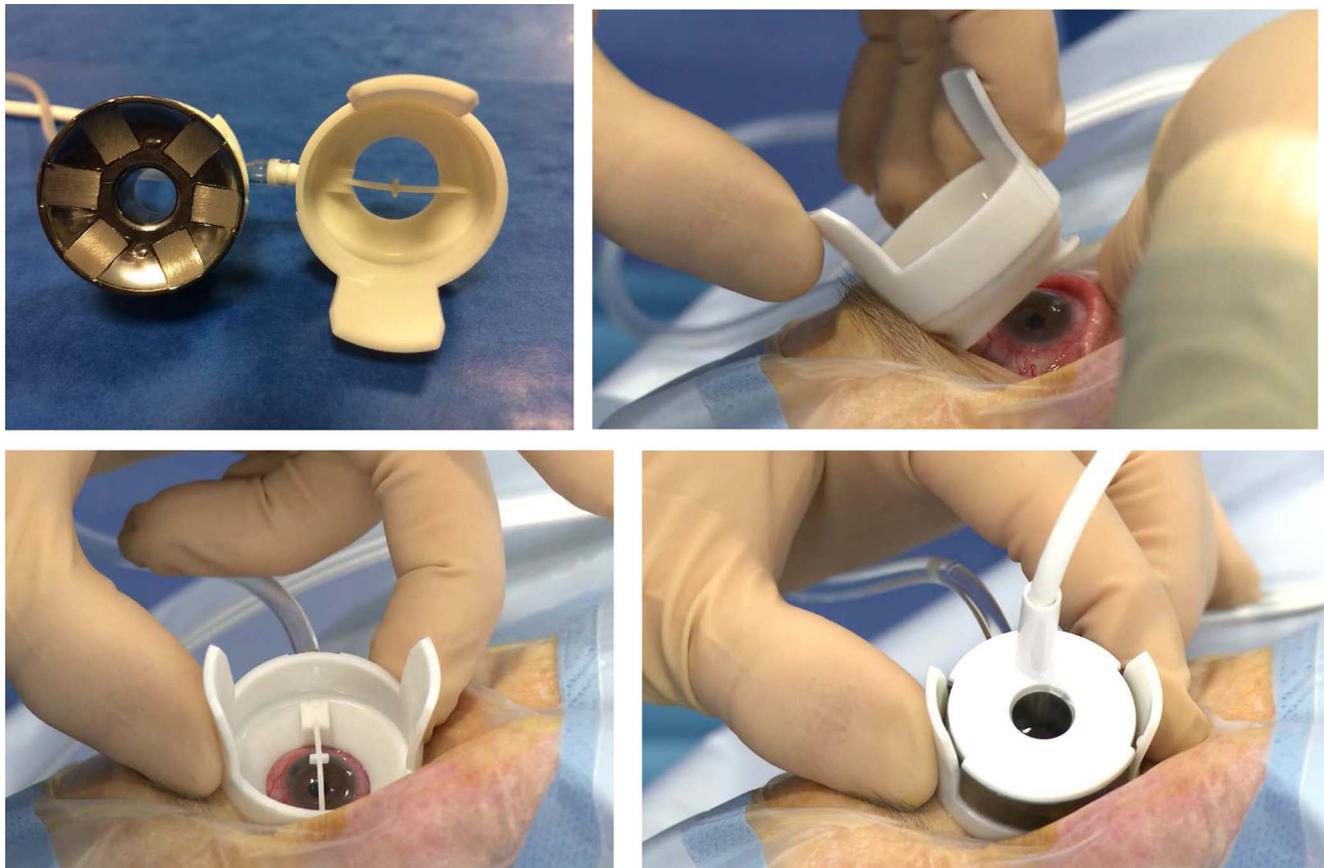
Top left:* High-intensity focused ultrasound device comprising two elements: the probe (*left*) with the six piezoelectric elements (transducers) generating the ultrasound beam, and the positioning cone (*right*). *Bottom left:* The cone in place showing a ring of visible sclera; when this ring is regular, the position is correct and then maintained by a mild vacuum system. *Bottom right:* The probe has been inserted in the cone and the device has been filled with physiological solution via the well in the middle. The treatment can start.
